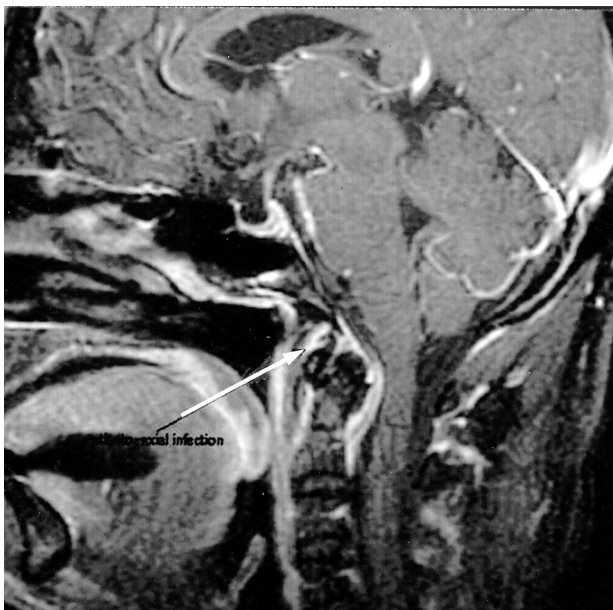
Sagittal T1-weighted magnetic resonance image with fat saturation and gadolinium enhancement showing robust soft tissue enhancement around the atlantoaxial joint and perivertebral tissues (arrow).
